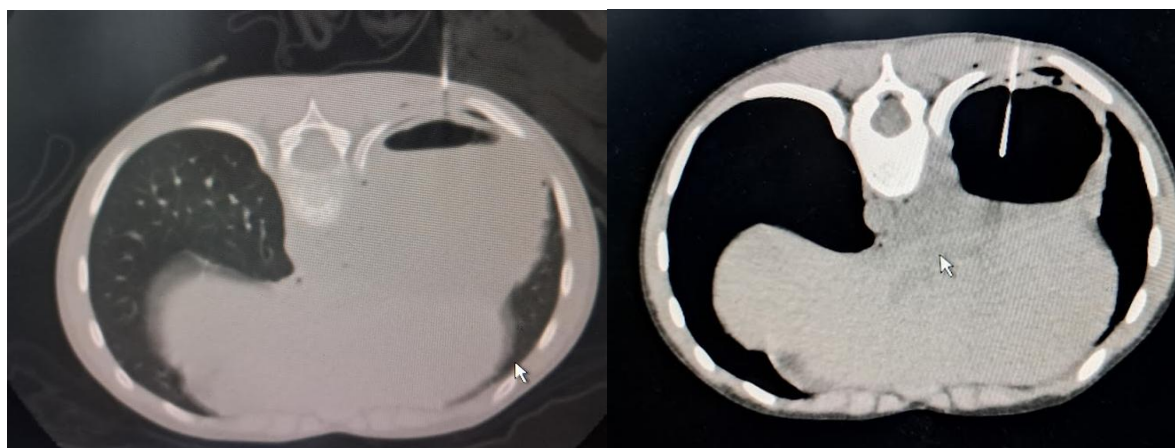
CT chest of a 3-year-old child who presented with an infected congenital pulmonary airway malformation, which progressed to a large lung abscess (Left). He had CT-guided aspiration, which completely settled the infection (Right)
